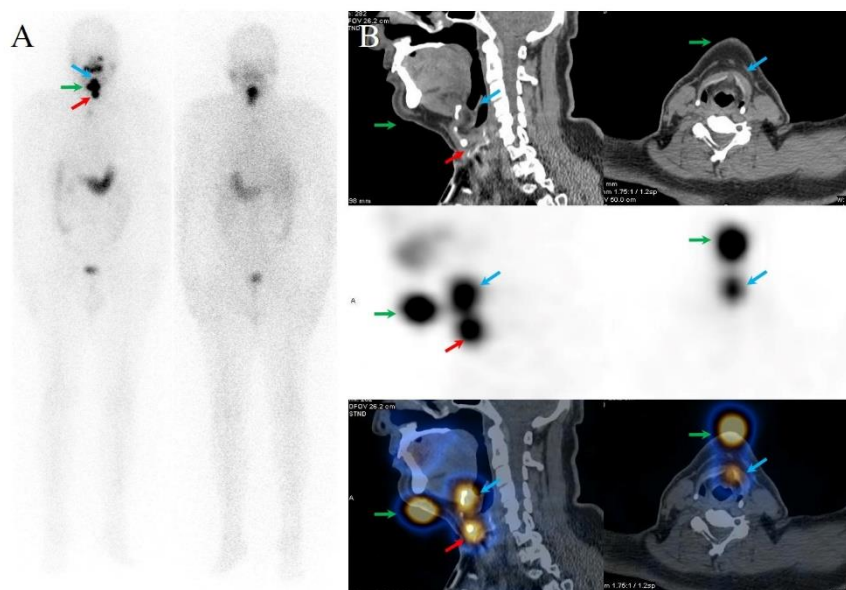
(A) The anterior projection of the whole-body radioiodine scan exhibits physiologic uptake patterns, accompanied by multiple sites of radioiodine accumulation in the central neck region, attributable to the thyroglossal duct remnant (blue arrow), iodine contamination on the mentum which was first considered as remnant in thyroid bed (green arrow), and residual thyroid tissue in the left thyroid bed which was assumed initially as possible lymph node metastasis (red arrow). (B) SPECT/CT imaging demonstrates that the uptake initially interpreted as thyroid bed remnant on the whole-body scan was, in fact, iodine contamination on the mentum (green arrow). Additionally, the focus regarded as possible lymph node metastasis on the whole-body iodine scan was confirmed to represent residual thyroid tissue in the left thyroid bed (red arrow). The remaining focus of radioiodine uptake was confirmed to represent the thyroglossal duct remnant, consistent with the initial presumption on the whole-body iodine scan (blue arrow).
